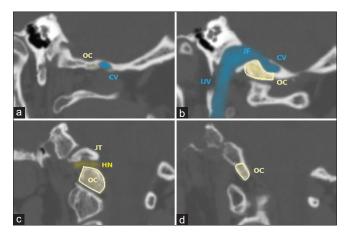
Reformatted thin-sectioned CT scan of the left occipital condyle. (a) section at the posterior tip of the occipital condyle, at the level of the occipital fossa, (b) section at the level of condylar vein branching off the internal jugular vein, (c) section at the level of the hypoglossal canal, (d) section at the most anterior tip of the occipital condyle. CV - condylar vein, OC - occipital vein, JT - jugular tubercle, HN - hypoglossal nerve, JF - jugular foramen, IJV - internal jugular vein, CT - Computed tomography
